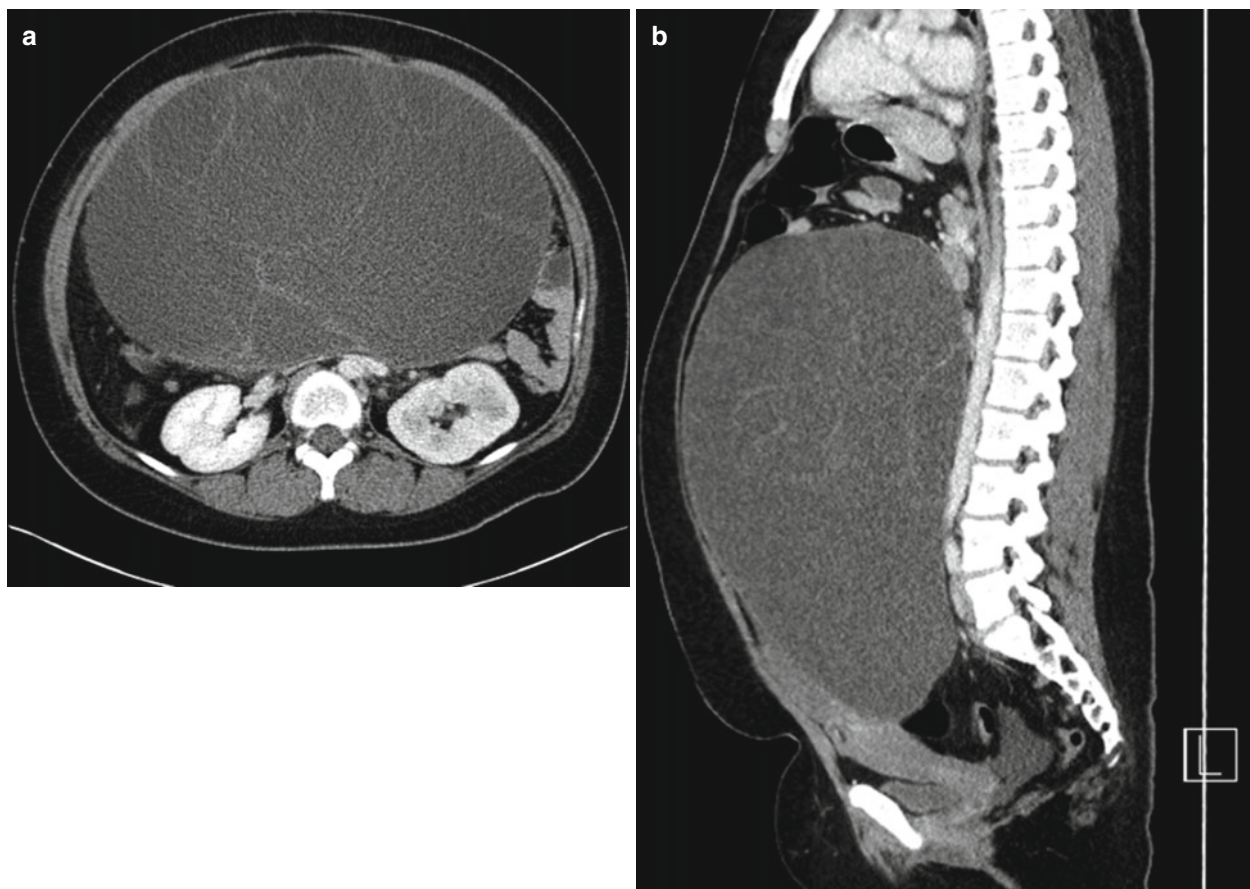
Serous cystadenoma in a 16-year-old girl. Contrast-enhanced axial (a) and sagittal (b) CT scans show multiseptated, huge cystic mass displacing the uterus anteriorly. Note that the locules of the mass have similar attenuation
